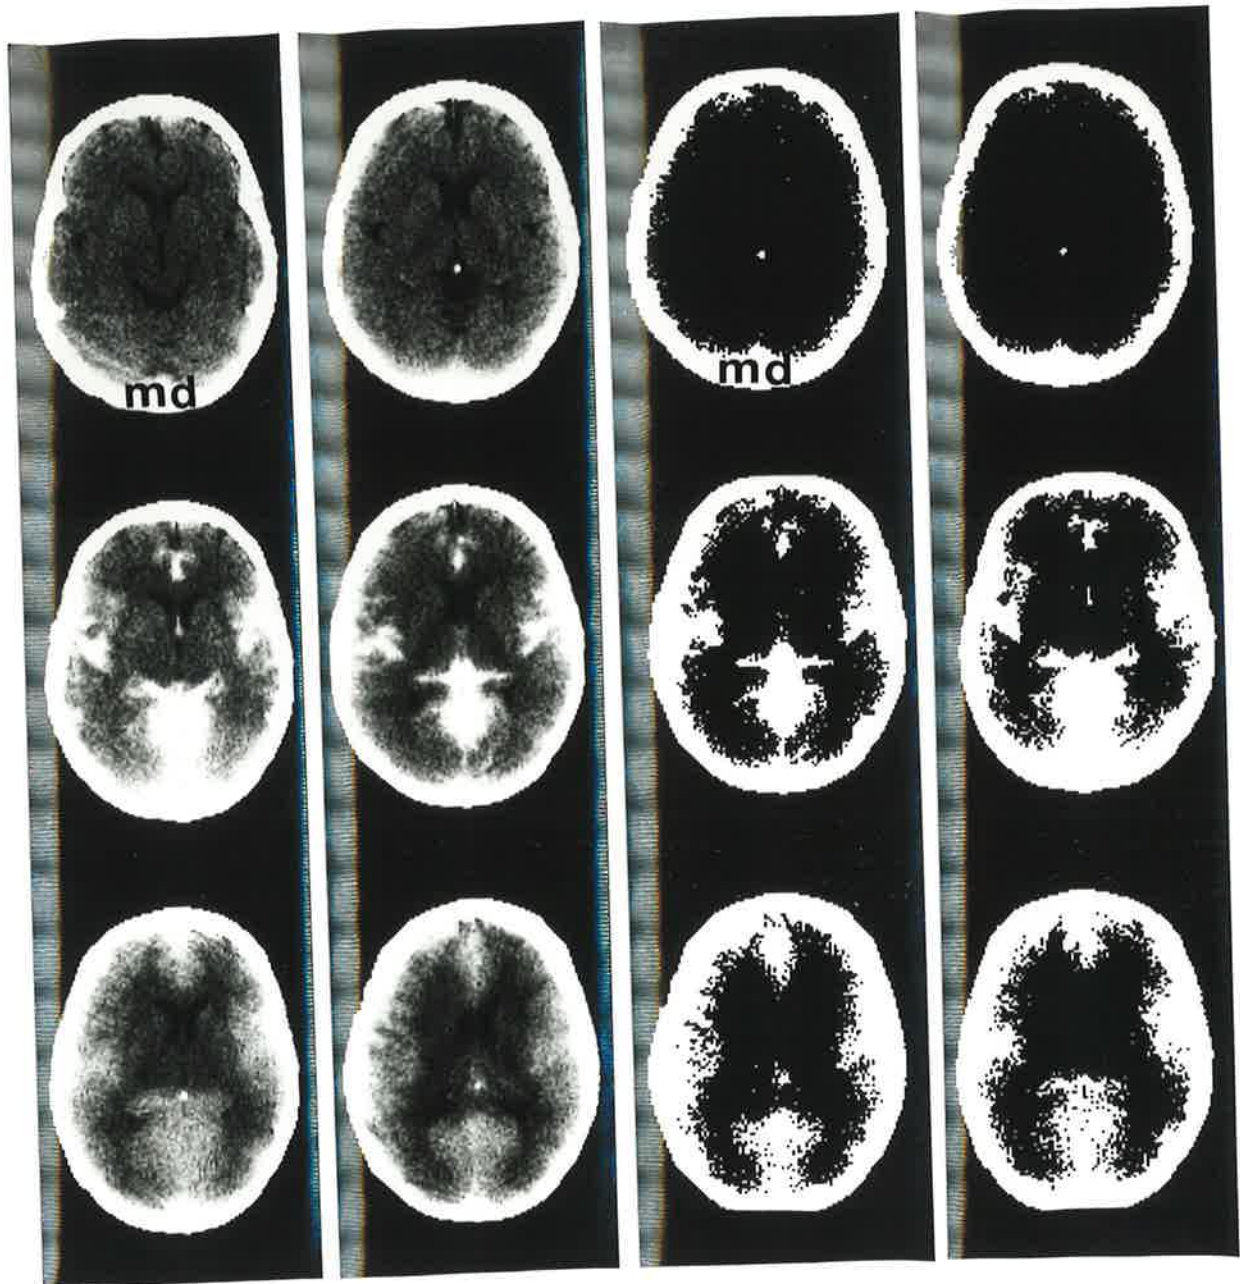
CT scans performed on a patient before (top) and at 6 (middle) and 24 (bottom) hours after lumbar myelography. A. Window setting of 30 EMI units. B. "Measure" setting similar to density of grey matter in control scan. At 6 hours, dense CM is noted in basal cisterns and sylvian fissures, without reflux into the ventricles. Brain penetration is noted. At 24 hours, dilute CM obscures the definition of the basal cisterns and sylvian fissures and CM brain penetration persists.
